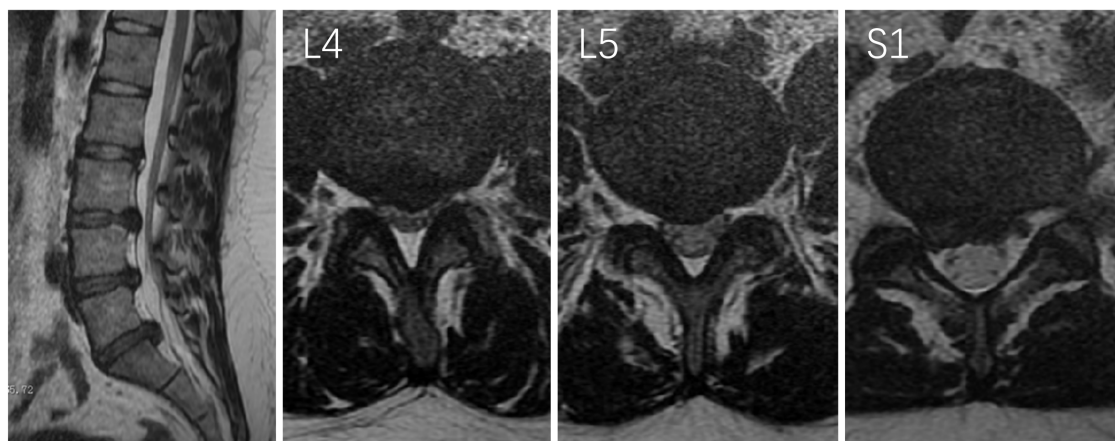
Preoperative MRI of lumbar spine showed herniated discs at L2/3, L3/4, and L4/5, prolapsed disc at L5/S1, and dural sac compression and canal stenosis in the corresponding segments
